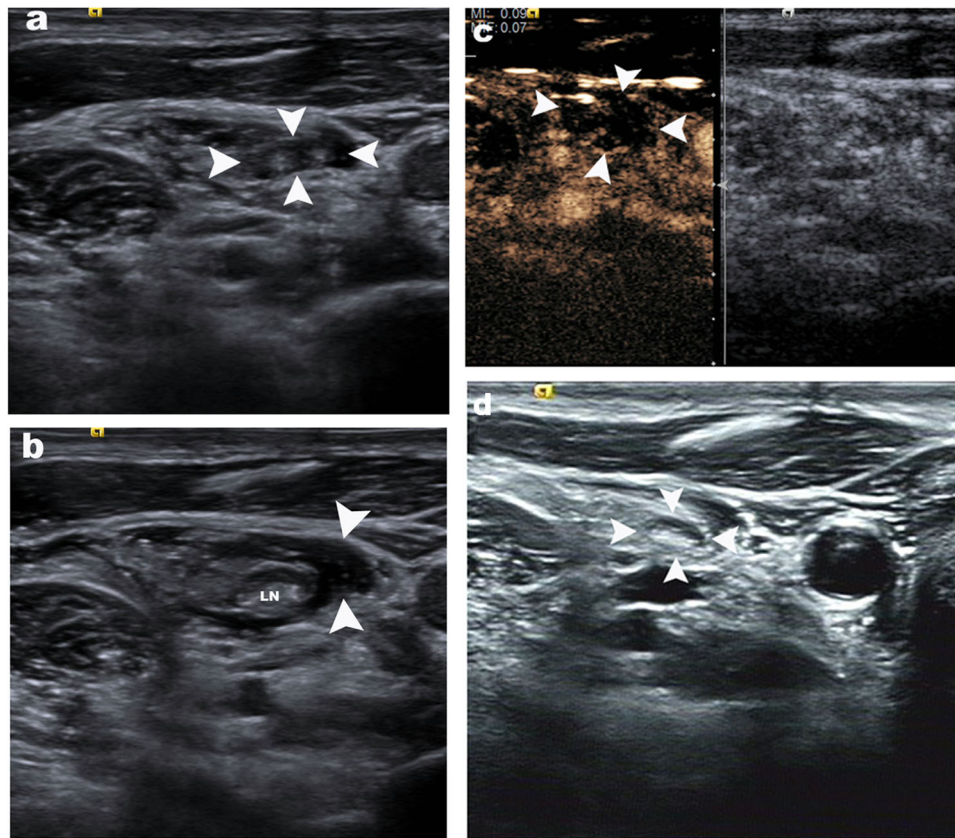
A 33-year-old female patient (no. 8) with cervical metastatic lymph node (CMLN) from papillary thyroid carcinoma (PTC) underwent microwave ablation (MWA). The ultrasound images before and after ablation are shown here. a A lymph node (LN) (white arrowhead) was detected in the level III of right neck. The size and volume of the LN were $14.3 \times 3.7 \times 7.0$ mm, and 192.59 mm^3 , respectively. b Before the MWA, a hydrodissection was conducted to prevent vital organs near the LN from burning. A normal saline area
